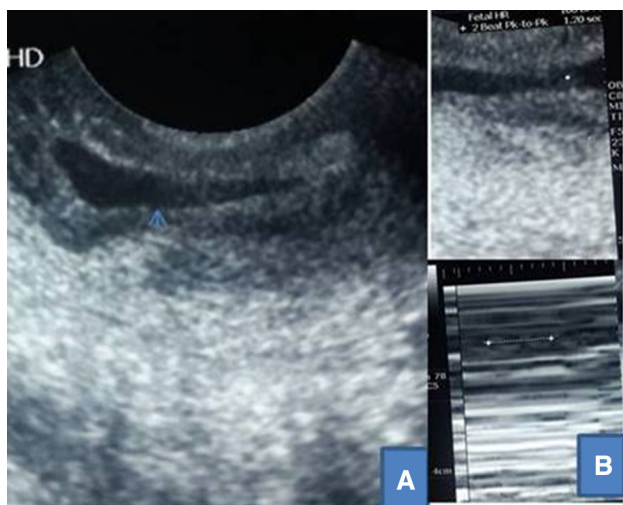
Ultrasonographic scan of the cervical pregnancy. a Empty uterine cavity (arrow) b mode scan depicting cardiac activity (lower inset) positioned in gestational sac (cursor in upper inset) which was lying below the closed internal cervical os. Presence of cardiac activity helps differentiating it from missed abortion
